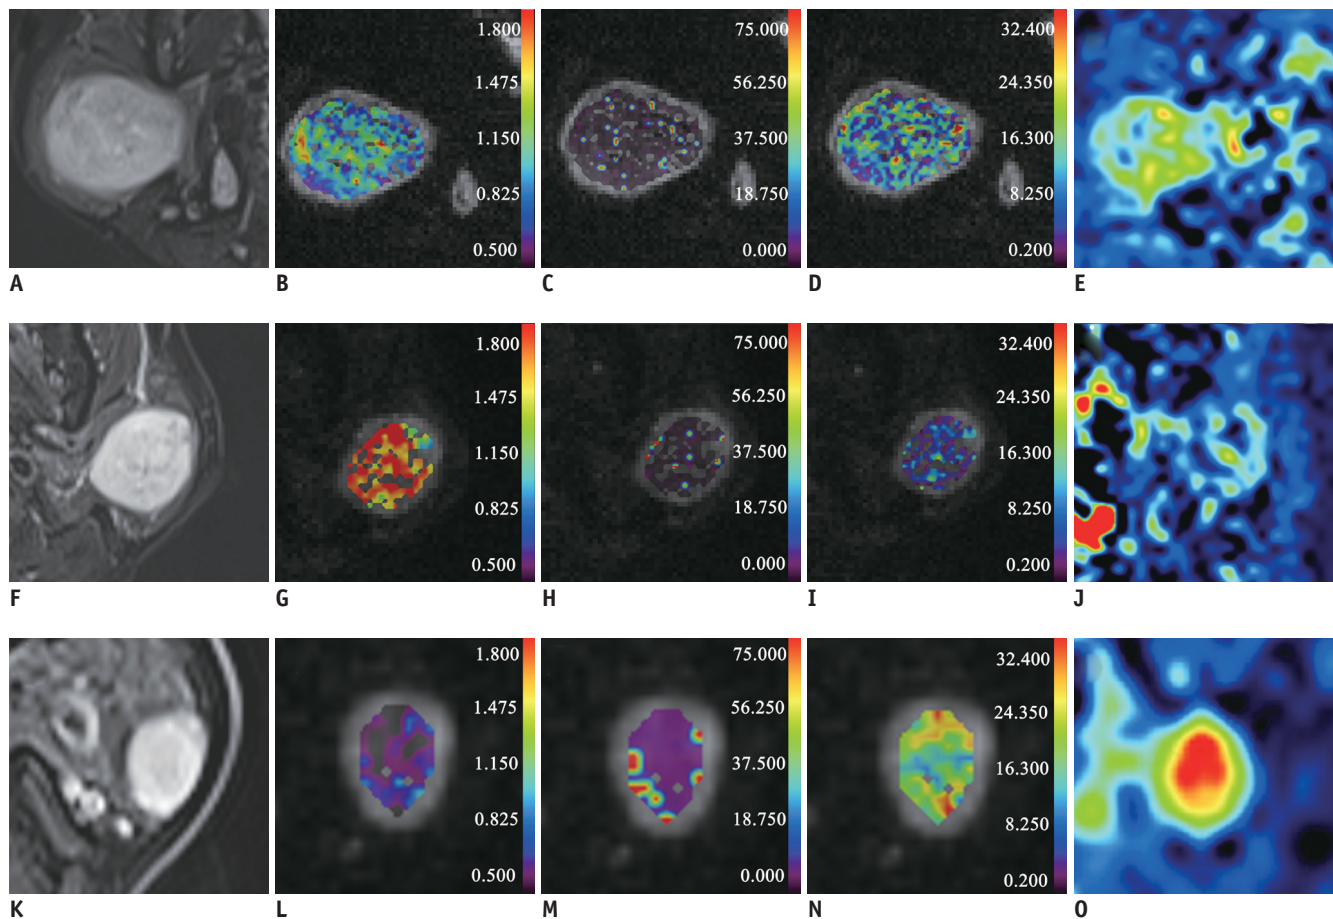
Representative images of acinic cell carcinoma (A-E), pleomorphic adenoma (F-J), and Warthin's tumor (K-O). The left column was the axial TSE-Dixon T2-weighted image (A, F, K). The following columns were colored D (B, G, L), D* (C, H, M), and f (D, I, N) maps embedded into the diffusion images (b_{1000} map) and ASL (E, J, O) maps. Corresponding maps showed a relatively higher D (G), lower D* (H), f (I), and ASL intensity (J) of pleomorphic adenoma than that of acinic cell carcinoma (B-E) and Warthin's tumor (L-O). The unit of D and D* is $\times 10^{-3} \text{ mm}^2/\text{s}$.
